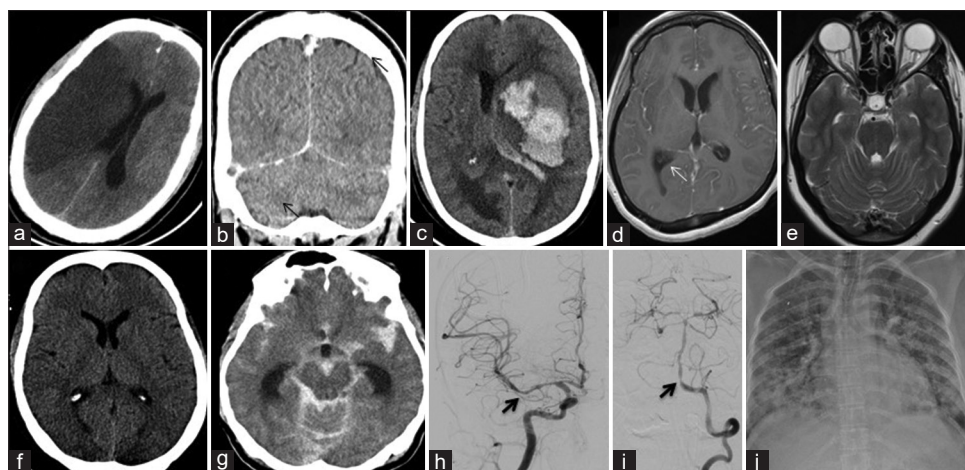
(a) Right middle cerebral artery territory infarct, (b) Superior sagittal sinus and right transverse sinus thrombosis; case of Cerebral venous sinus thrombosis. (c) Left basal ganglia bleed with variable densities suggestive of Cerebral venous sinus thrombosis. (d) T1 axial image with post contrast enhancement in a case of Meningitis. (e) T2 axial images of the Brain showing partial empty sella with tortuous optic nerves in a case of IIH (idiopathic intracranial hypertension). (f) Hypodensity in bilateral Occipital region suggestive of posterior reversible encephalopathy syndrome (PRES). (g) Hyperdensity of the sylvian fissure and all the basal subarachnoid spaces suggestive of Subarachnoid haemorrhage. (h and i) Digital subtraction angiogram showing multifocal stenosis and ectasia of middle cerebral artery and posterior cerebral artery (Arrows). (j) X-Ray of patients showing diffuse (More in bilateral lower zone) pulmonary infiltrates
